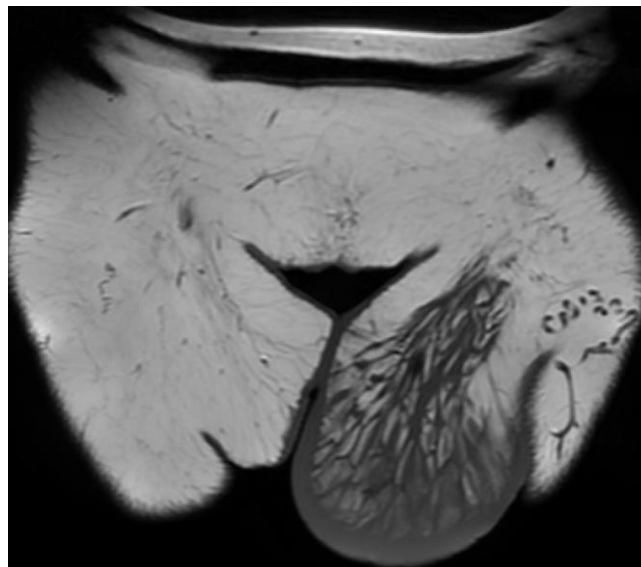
Coronal T1-weighted MRI image
